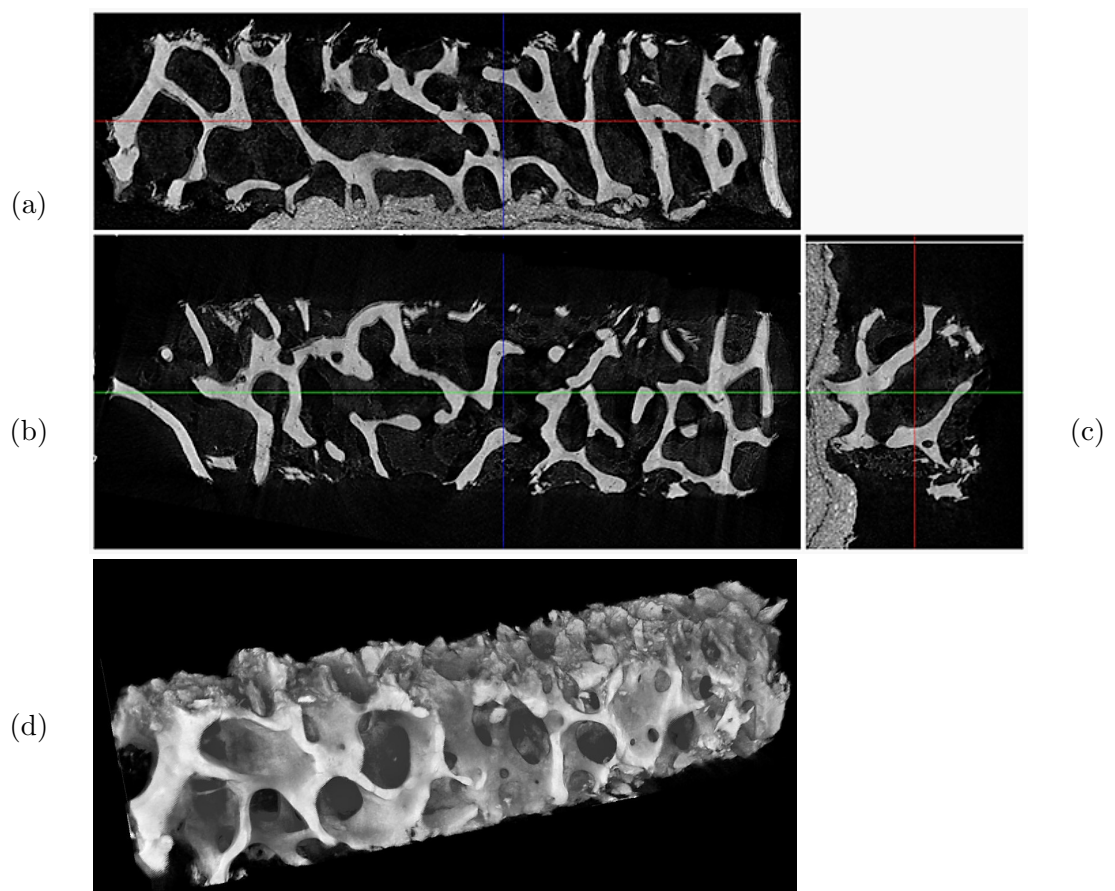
(a) Frontal (b) sagittal (c) transverse and (d) 3D representation of the μ CT reconstruction of metaphyseal tissue recovered by Trephine needle
